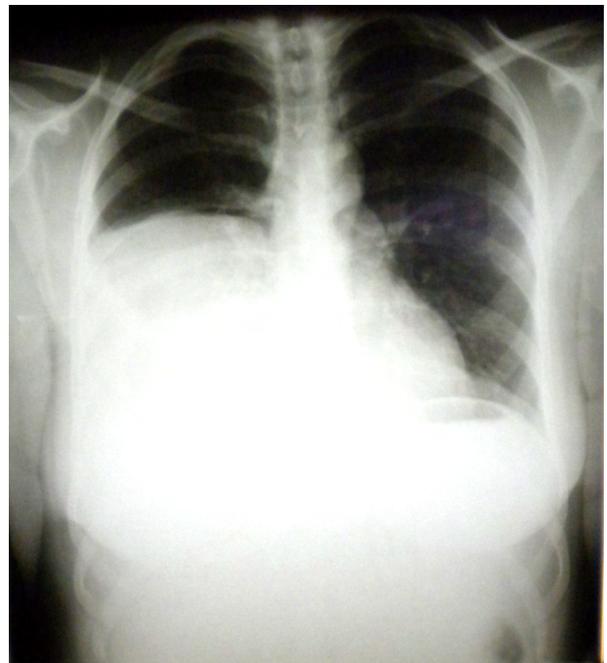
A chest radiograph showing large amount of right-sided pleural effusion.
